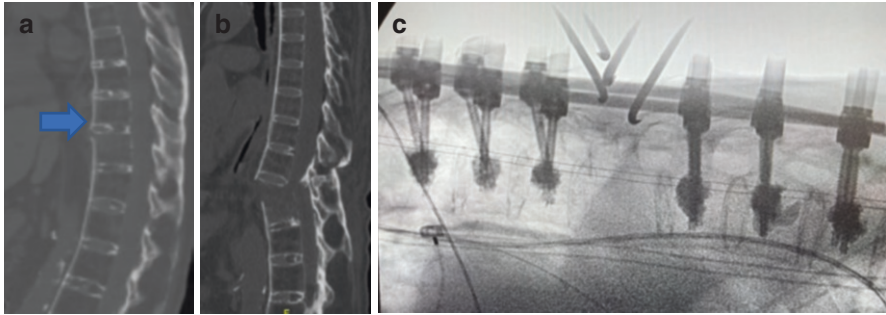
(a) Sagittal CT demonstrating bridging bone throughout the thoracic spine consistent with ankylosing spondylitis. A fracture through the T10 superior endplate is marked with a blue arrow. (b) A subsequent CT taken after repositioning demonstrates loss of alignment. (c) Lateral fluoroscopy demonstrating posterior fusion 3 levels above and below the fracture level
